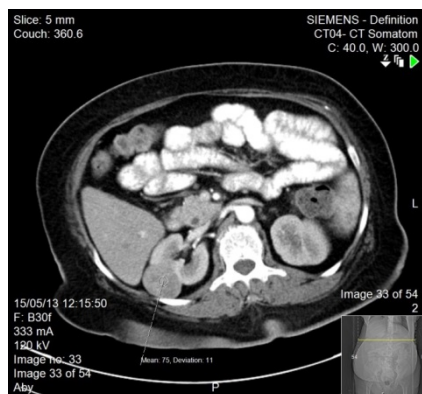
CT of the abdomen showing right kidney mass
